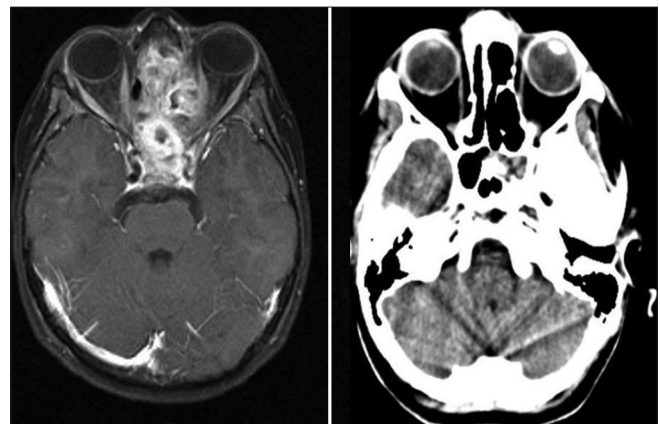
Pretreatment MRI on the left. 3 years post chemoradiation computed tomography scan showing no evidence of disease
